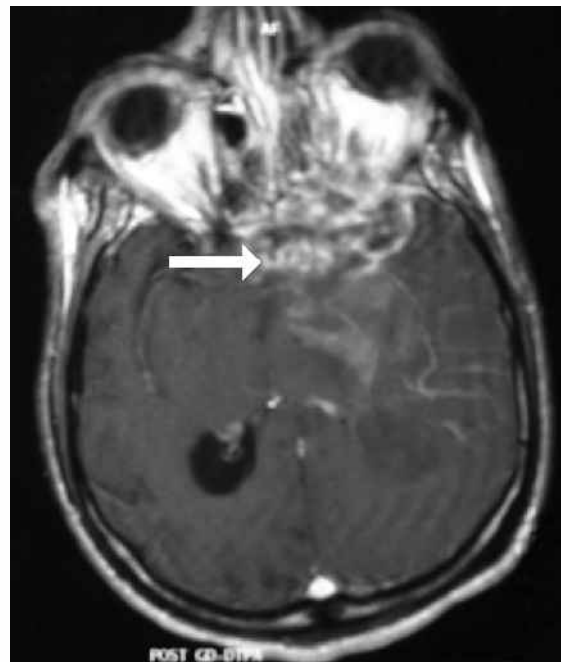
Contrast-enhanced axial T1-W MR image of the brain shows enhancement of the mass (arrow) in the left sphenoid sinus and temporal lobe.
